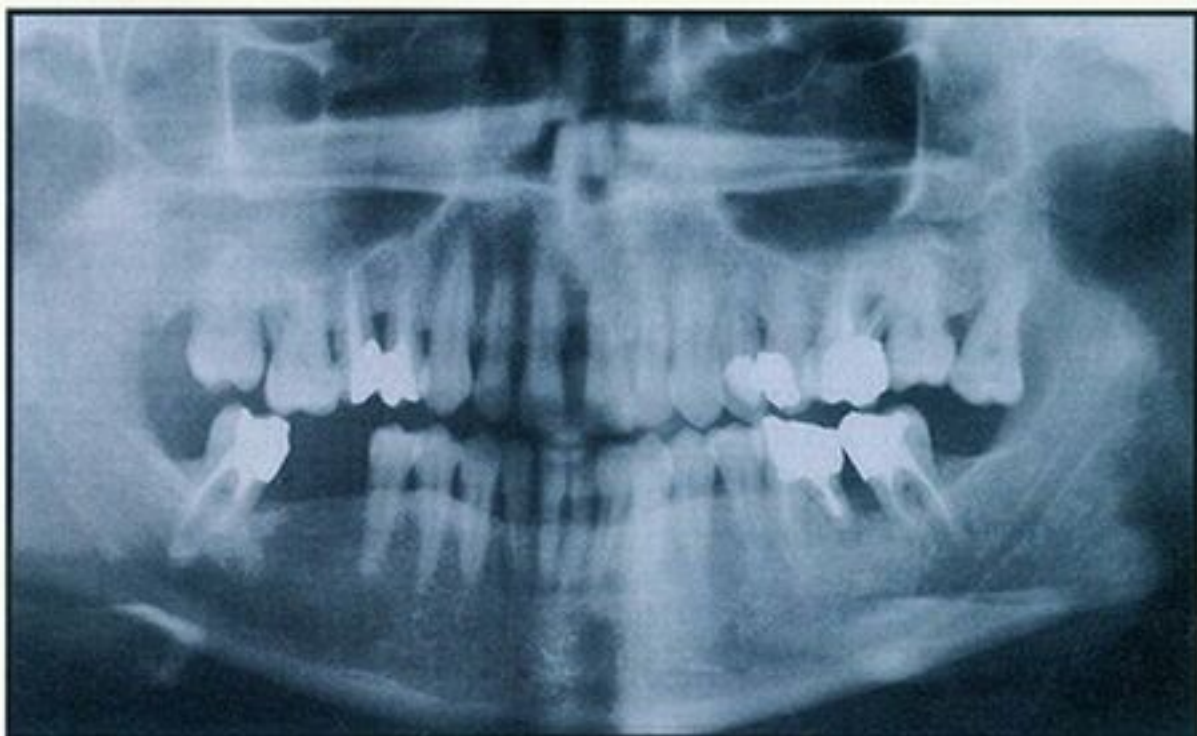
Preoperative panoramic radiograph. Note generalized moderate to advanced bone loss.
